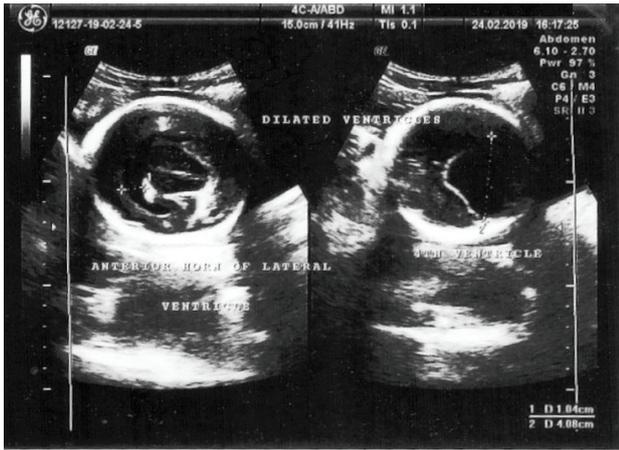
Sonographic measurement of fetal lateral ventricles in the axial trans-ventricular plane showing enlarged and dilated bilateral ventricles. Anatomical delineation cavum septum pellucidum was not demonstrable.
